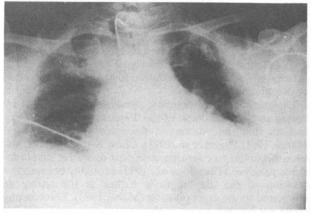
Post-operative X-ray chest (day 2), AP view.
